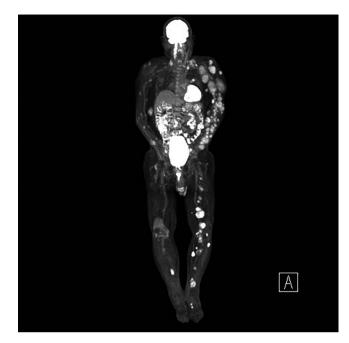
Extensive hypermetabolic deposits noted particularly on the left side at first PET-CT staging scan.
